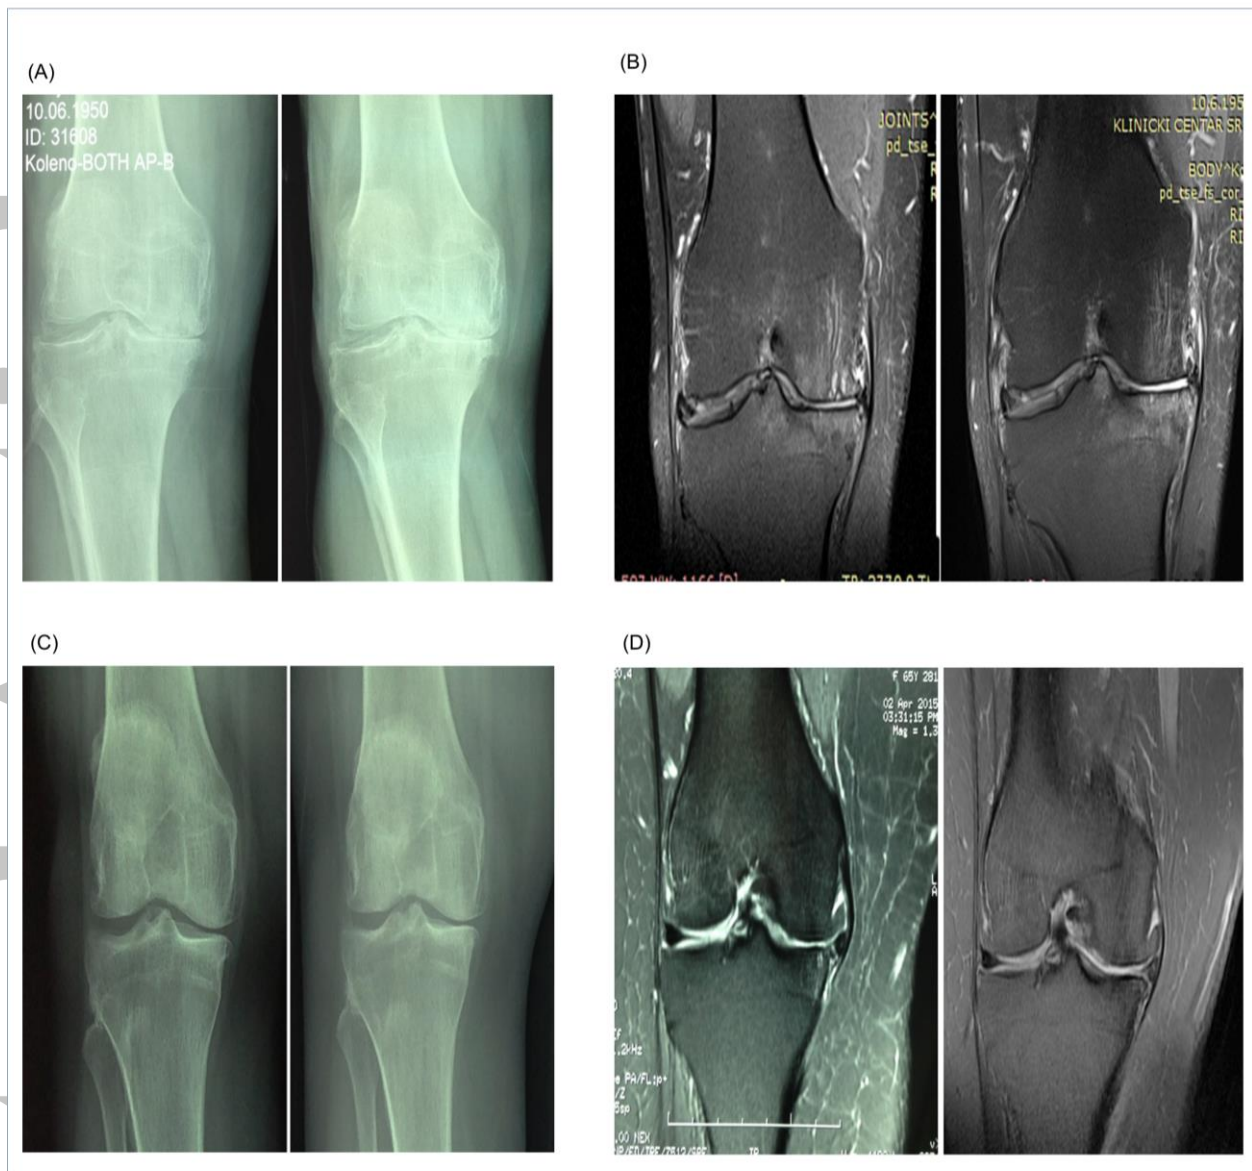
Figure shows results on a digital plain radiography and MRI before the treatment and after 18 months of follow-up. Figure 2A. Patient #1, right knee digital plain radiography before the treatment (left) and after 18 months of follow-up (right). Figure 2B. Patient #1, right knee T1 sequence MRI before the treatment (left) and after 18 months of follow-up (right) Figure 2C. Patient #2, right knee digital plain radiography before the treatment (left) and after 18 months of follow-up (right) Figure 2D. Patient #2, right knee T1 sequence MRI before the treatment (left) and after 18 months of follow-up (right)
